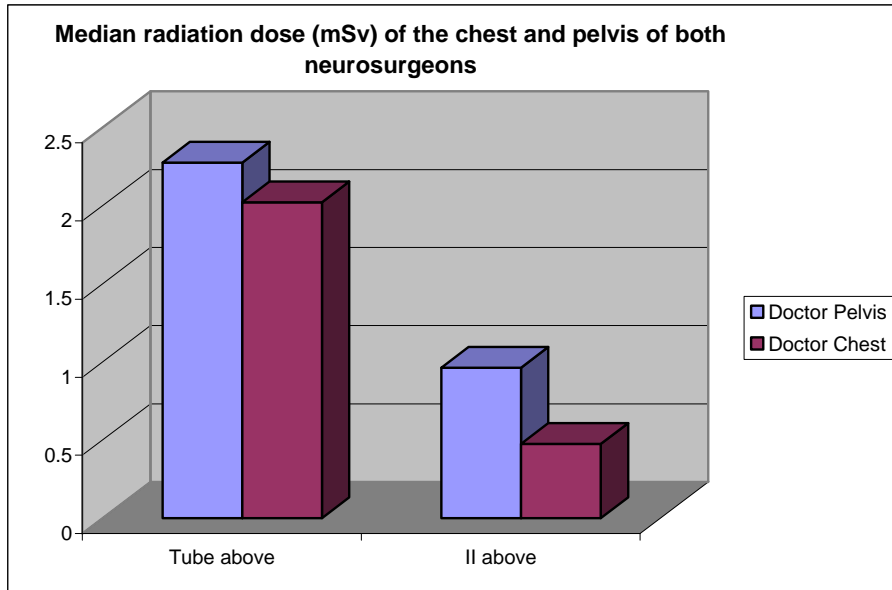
The pelvis and chest dose values of the neurosurgeons with x-ray tube and II respectively above the table
